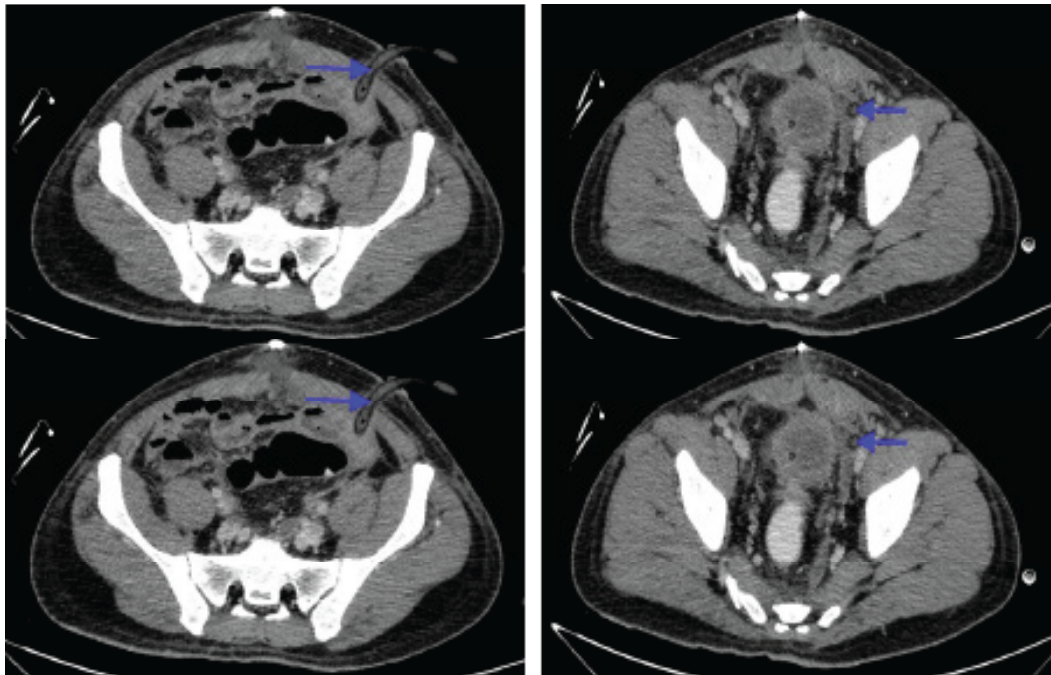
Axial images of CT Abdomen and Pelvis for Patient B. CT scan done upon presentation shows generalized dilatation of small and large bowels (A) with small pelvic abscess (B). Images from repeated CT scans (note the corrugated drain after incision and drainage of the perianal abscess were performed (C) after non-resolved abdominal sepsis, which shows the increased size of the ischiorectal abscess (D+E) with extension to the pelvic cavity (F) as shown by the blue arrows.
